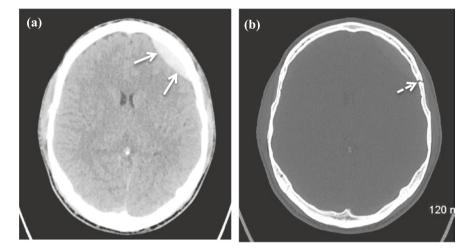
A 30 year old man sustained a head injury after falling from a height. He complained of a headache on presentation (GCS 15) but after a short period became confused became drowsy (GCS 13). An emergency CT brain was performed. This demonstrates a biconvex hyperdense extra-axial collection adjacent to the left frontal lobe which obeys the suture lines (a). This is an acute extradural haemorrhage. On the bone reconstruction image (b), there is a non-displaced fracture of the left frontal bone. The patient underwent emergency surgical decompression of the haematoma
